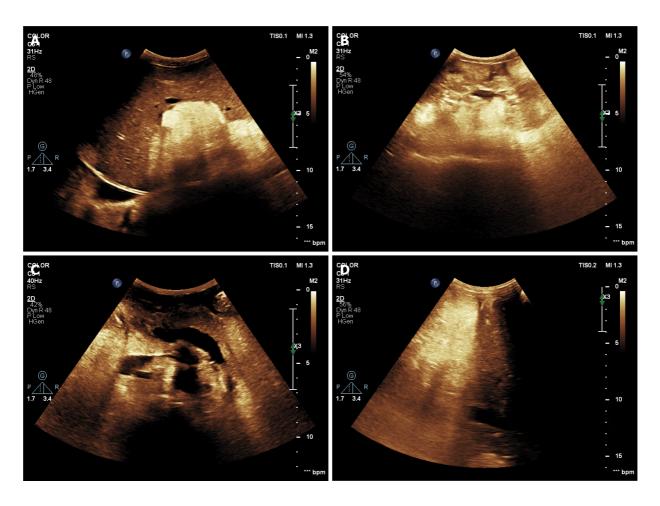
Ultrasonography revealed multiple high echogenic masses. A: Liver; B: Right kidney; C: Retroperitoneum; D: Inferior mediastinum.
